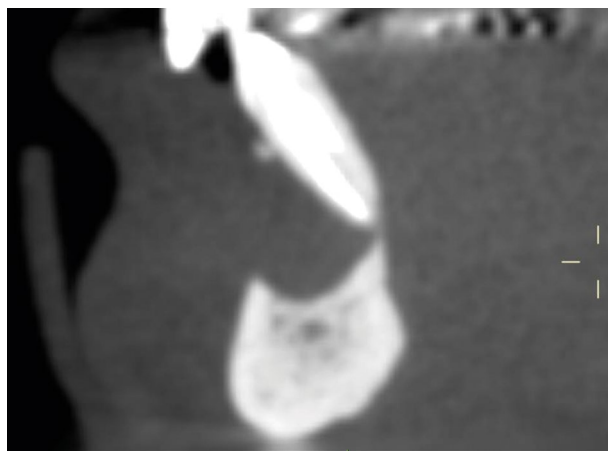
Sagittal radiographic section of a previously traumatised 31 that has been endodontically treated to reduce the size of the large periapical lesion
